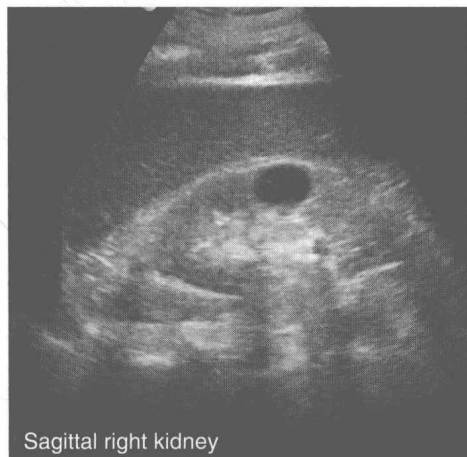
Incidental finding on abdominal ultrasound.
